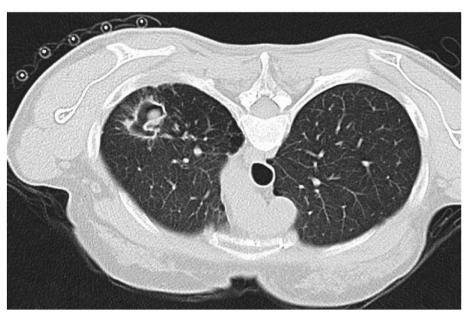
Chest CT showing a mass in the pulmonary cavity.
